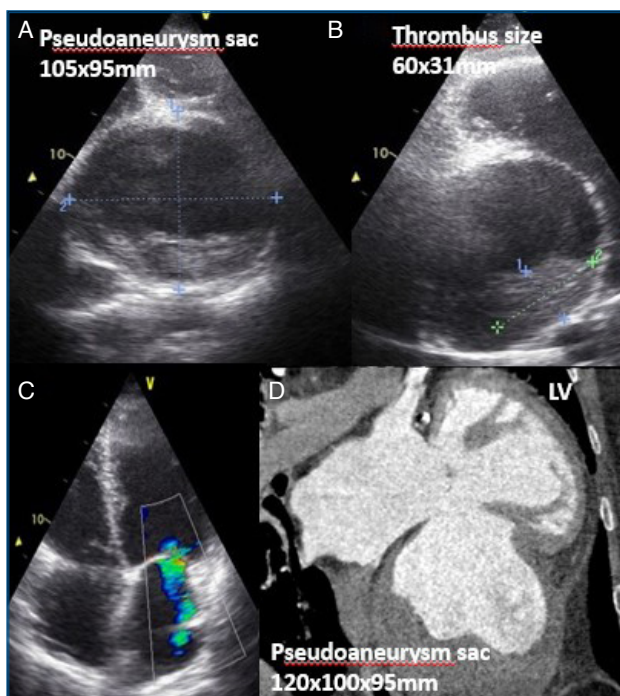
(A-C) Echocardiographic evaluation shows an aneurysm of 105 × 95 mm and a thrombus of 60 × 31 mm in a patient with severe eccentric mitral regurgitation. (D) Computed tomography angiography image shows an enlarged aneurysm sac (120 × 100 × 95 mm), and thrombus is present.
